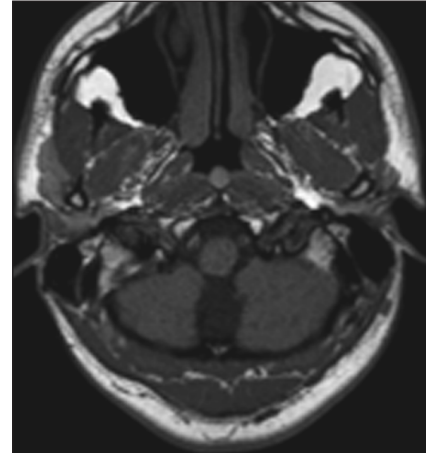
The patient's magnetic resonance imaging view at third admission.
